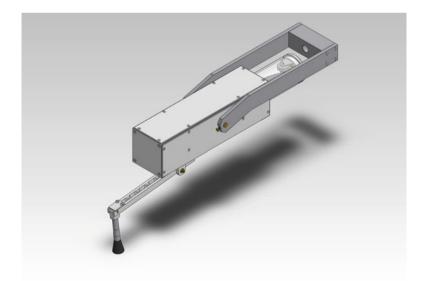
The Linear Tactile Stimulator (LTS), engineered by Dancer Design (UK), of utility in MRI environments
